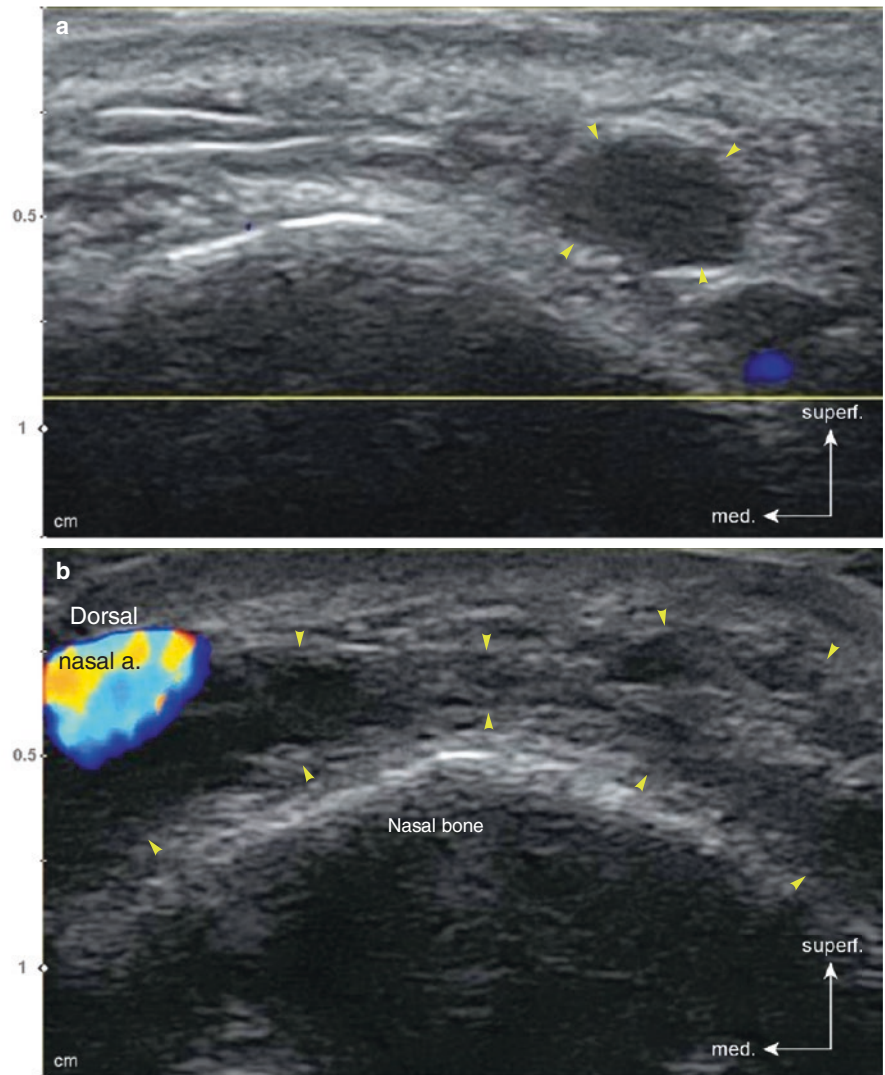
Ultrasonography of the silicone implant on the dorsum of nose. (a) B mode (transverse view, 15 MHz by linear transducer) and (b) B mode (longitudinal view, 15 MHz by linear transducer). (Published with kind permission of © Ji-Soo Kim 2020. All Rights Reserved)
